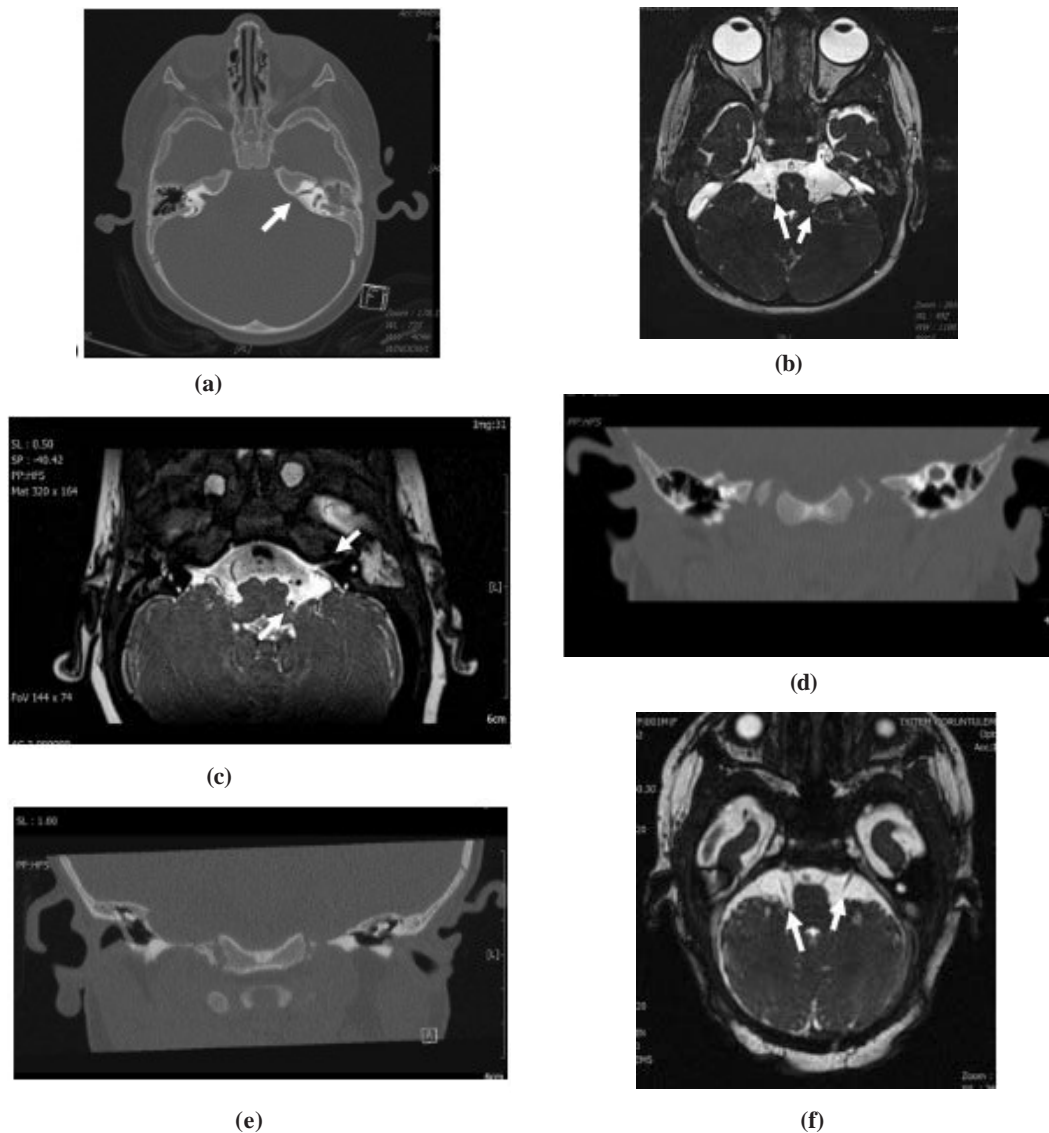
a) Advanced hypoplasia was demonstrated in the left internal acoustic canal in temporal bone CT of case 1; b) The hypoplastic left 7th-8th nerve complex derived from the brainstem in the form of two separate anatomical structures showed a uniform single nerve at the entrance of the canal, which extended into the canal in this form in ICA MRI of case 1; c) The absence of bilateral inner ear structures was observed in the Temporal Bone CT evaluation of case 2; d) In the ICA MRI evaluation of the case 2, bilateral inner ear structures, intracranial segments of the 7th and 8th right nerve and 7th left cranial nerve were not observed; 8th left nerve was in fine calibration and the current pathology was consistent with Michel's aplasia; e) Temporal bone CT examination of the case 3 revealed that bilateral cochlea, vestibule and semicircular canals were not observed (complete labyrinthine aplasia); f) In the ICA MRI evaluation of the case 3, bilateral aplasia of the 8th nerves and intracranial segments of the 7th nerves were detected.
